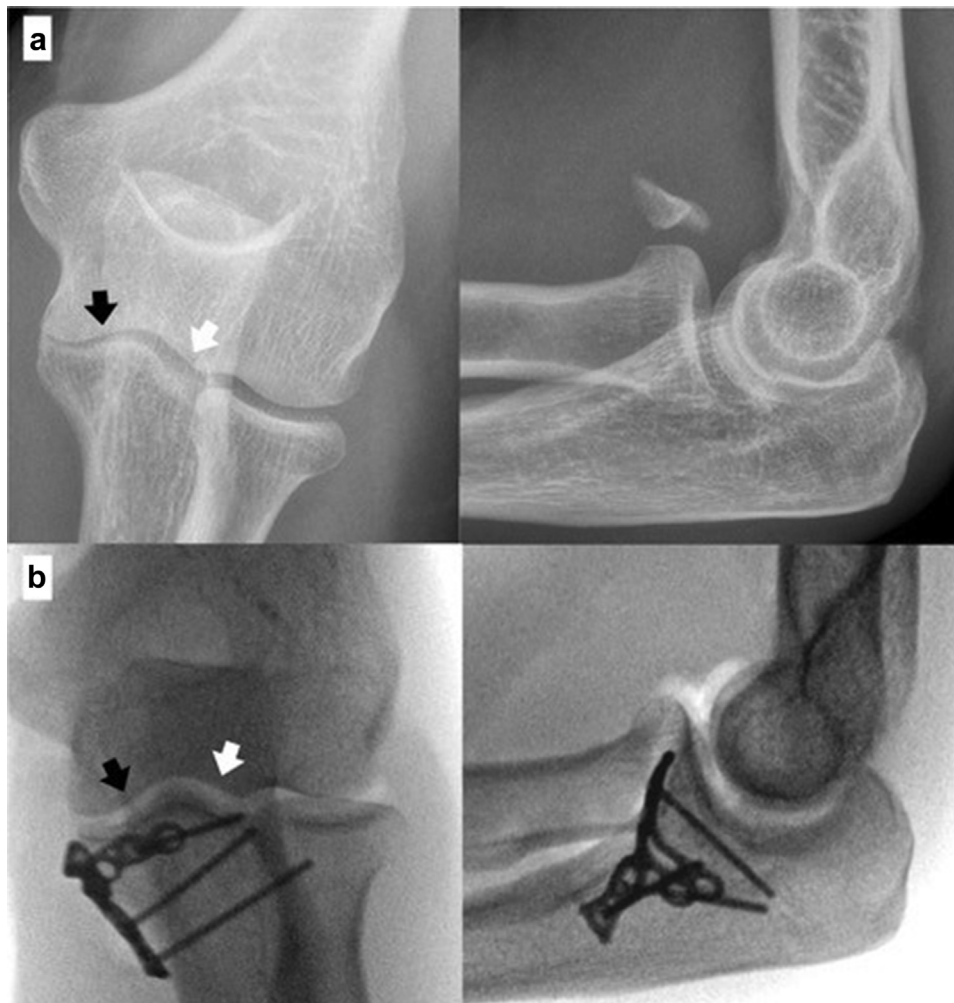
(a) Anteroposterior and lateral radiographs of patient with anteromedial subtype 2 fracture. On should note the static varus subluxation on the anteroposterior radiograph, indicated by relative narrowing of the medial ulnohumeral joint space (▲) compared with the normal lateral ulnohumeral joint space (white arrow). The presence of static instability seen on imaging was an indication for fixation of the anteromedial coronoid fracture. (b) Following buttress plating, a congruent joint space has been restored as indicated by the arrows. The lateral collateral ligament was repaired with an all-suture anchor (radiolucent).
